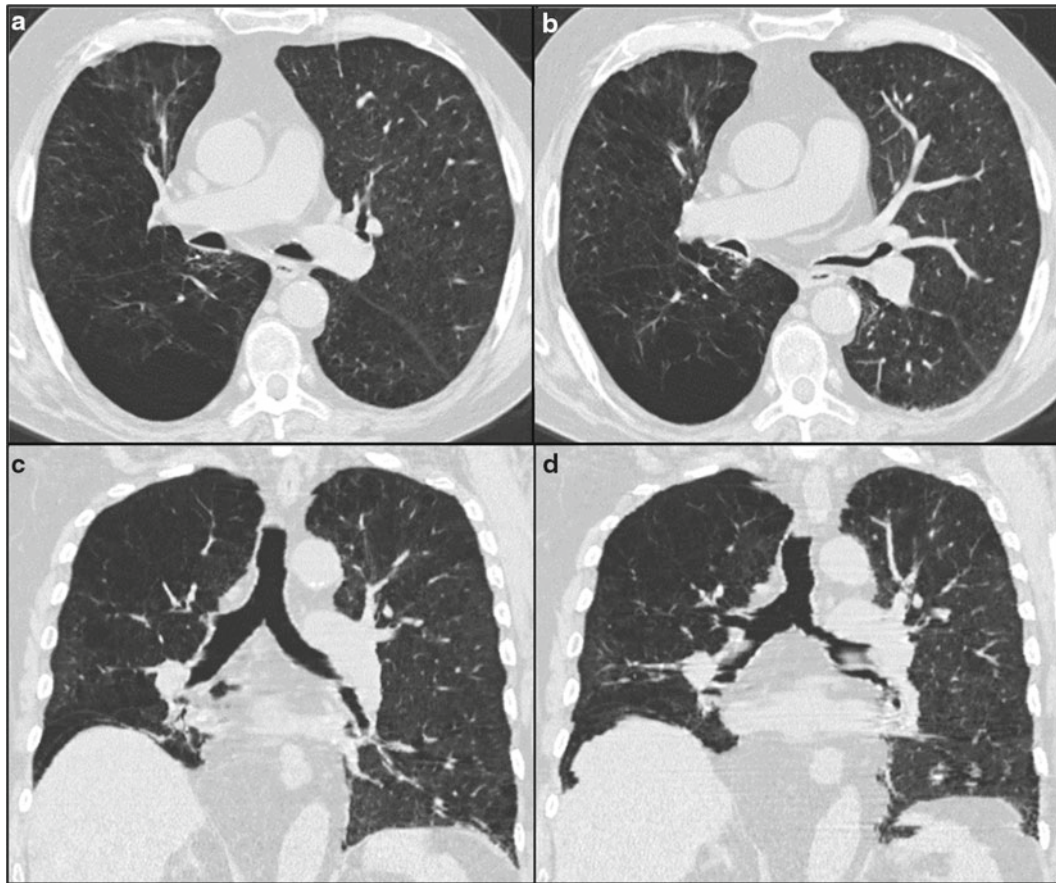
The 81-year-old patient acquired 40 pack years and suffered from COPD III. He was planned for interventional emphysema therapy and therefore underwent paired inspiratory (a + c) and expiratory (b + d) thin-section CT scan. The comparison of the mainstem bronchi at inspiratory and expiratory CT indicates a relevant luminal change. The coronal reformat of the expiratory scan shows severe staring artifacts due to respiratory effect (d): Expiratory breath holding requires more
